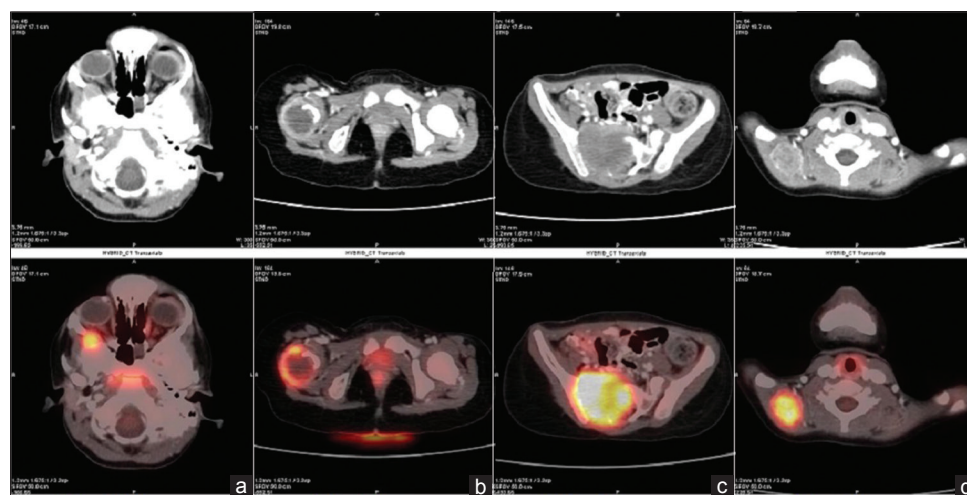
Transaxial computed tomography and fusion positron emission tomography-computed tomography images on F-18 fluorodeoxyglucose positron emission tomography-computed tomography scan showing fluorodeoxyglucose avid hypermetabolic foci in soft-tissue lesions involving; (a) right zygomatic bone with intraorbital extension, (b) right proximal femur, (c) sacrum and right sacroiliac joint, and (d) right suprascapular region
